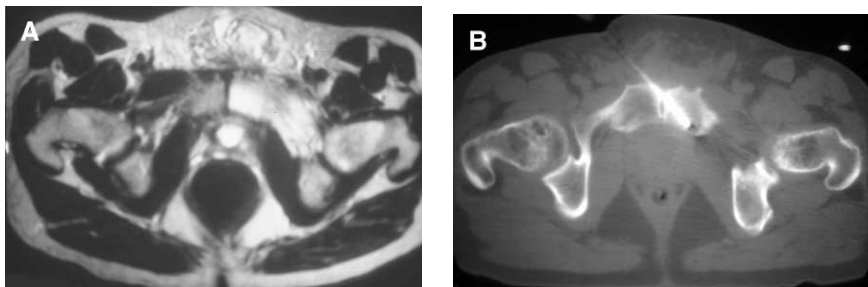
Fifty-five-year-old male with pain in the pubic region after transabdominal resection of prostate cancer. Axial T2 weighted image at the level of the pubic symphysis (A) demonstrates increased signal in the left pubic ramus suspicious for osteomyelitis. CT guided biopsy (B) of the left pubic ramus demonstrated acute osteomyelitis.
